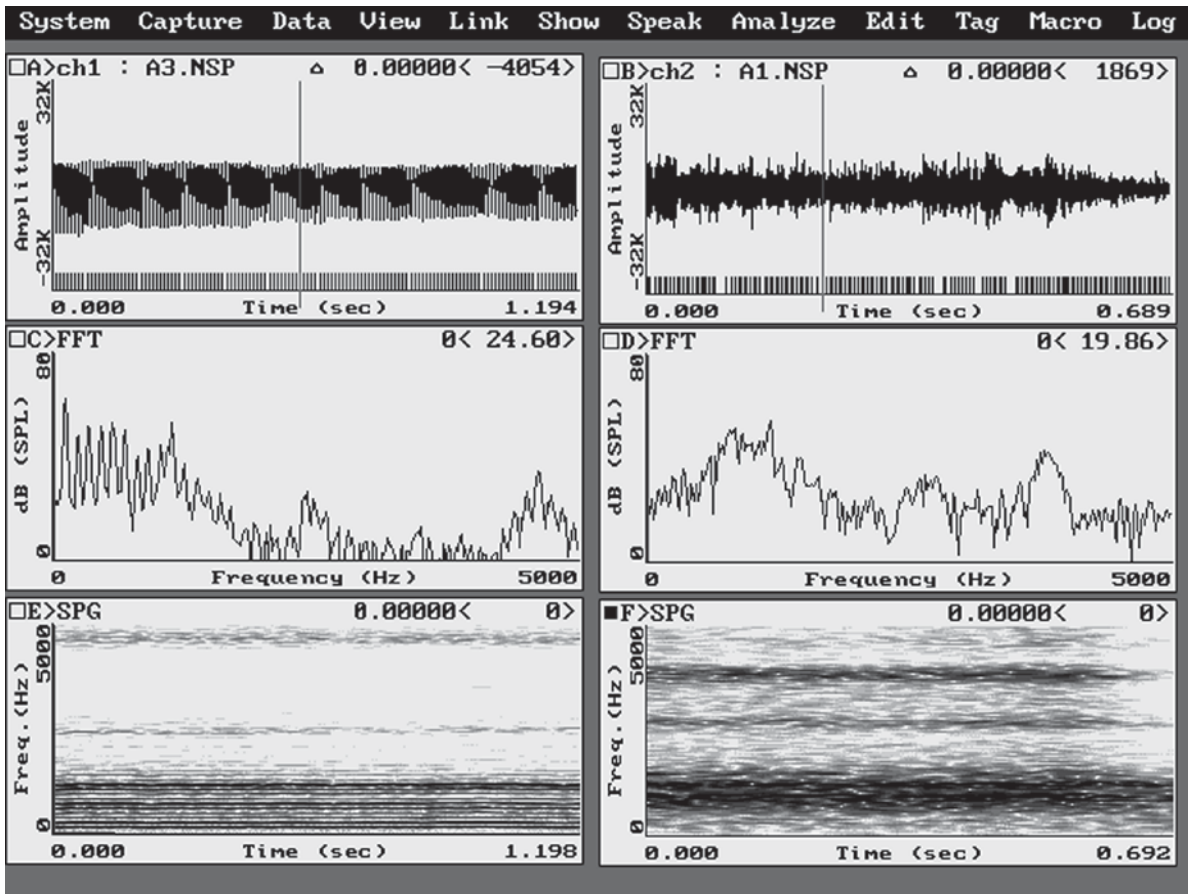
Visible speech or sonagraphy, as displayed by the Computerized Speech Laboratory (Kay Elemetrics, Lincoln Park, NJ, USA). Sustained /a/: on the left by a normal voice and on the right by a breathy voice. From top to bottom : microphone signal), power spectrum (0–5000 Hz), and spectrogram (sonogram), frequency display 0–5000 Hz over time: about 1.2 s left
